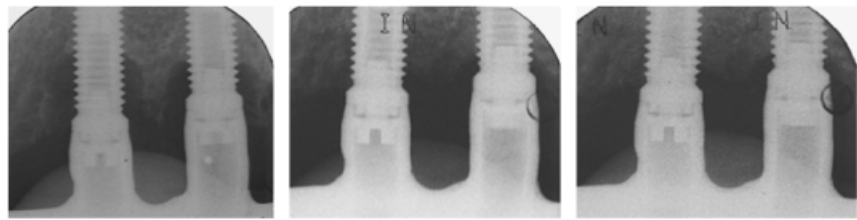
Examples of radiographs taken from one subject at baseline, year 1, and year 3 after follow-up.
